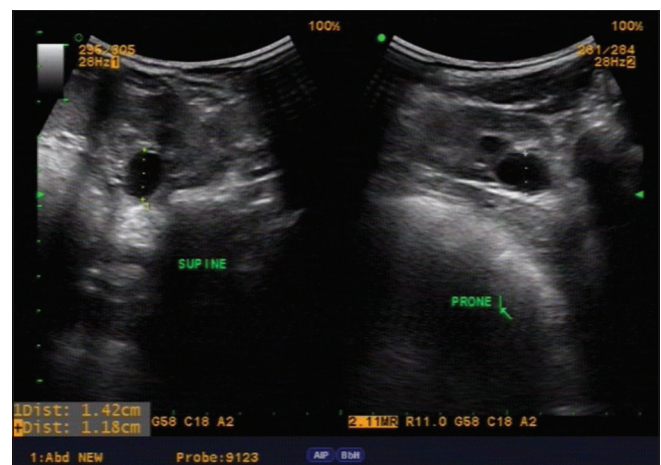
Post Pyeloplasty ultrasound showing APD of 1.42 cm in supine and 1.18 cm in prone position
